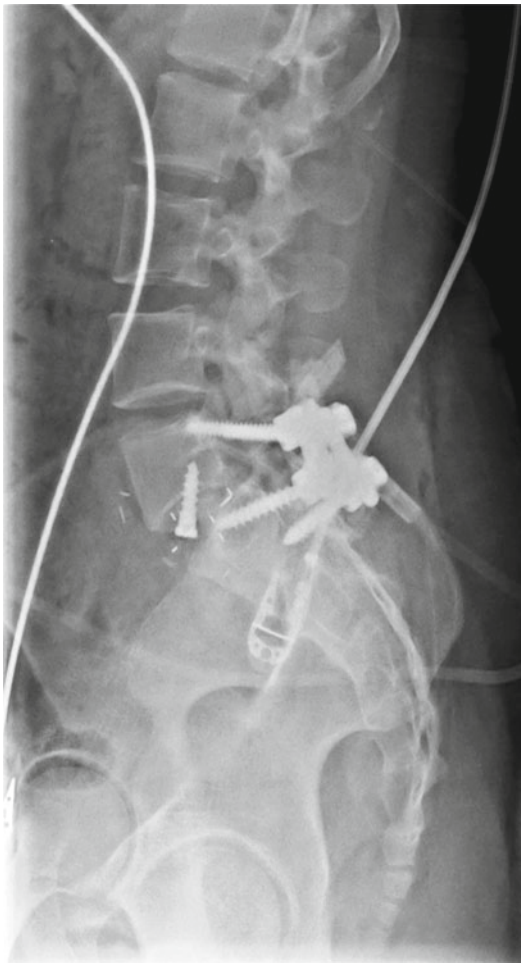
Lateral radiograph of the lumbar spine showing the instrumentation construct of the spinal fusion
